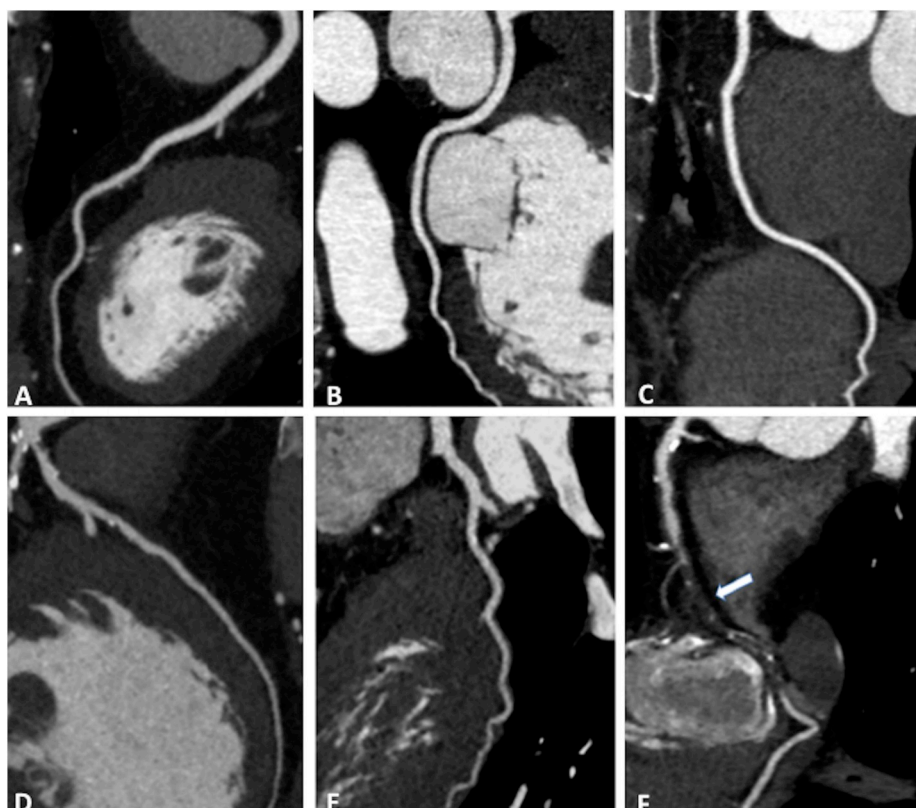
Upper row: A 53-year-old woman with family history of cardiovascular disease, palpitations and dyspnea. CAD RADS 0: (A) absence of pathology in the left anterior descending artery, (B) circumflex artery and (C) right coronary artery. Lower row: A 67-year-old man with dyslipidemia and severe left ventricular dysfunction by echocardiography. CAD RADS 5: (D) severe stenosis of the proximal left anterior descending artery, (E) absence of pathology of circumflex artery and (F) occlusion of mid portion of right coronary artery (arrow).
